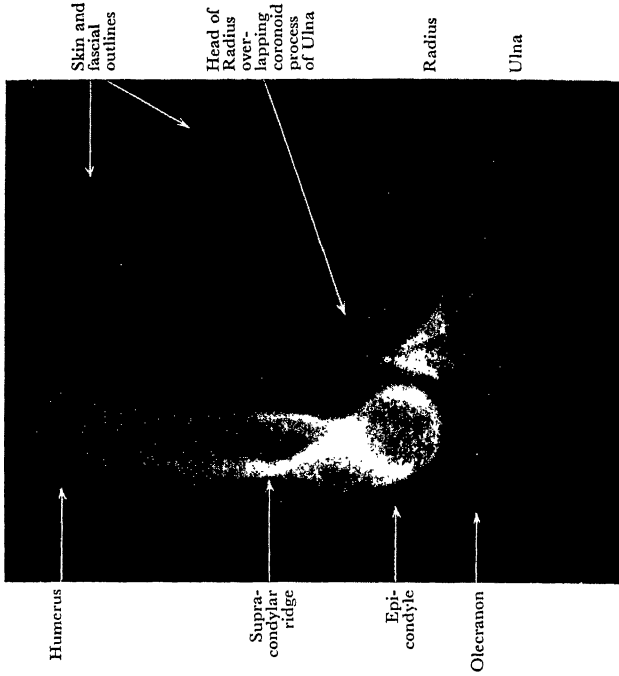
Lateral Radiograph of same Elbow half-flexed. Note the relative position of epicondyle and olecranon.
